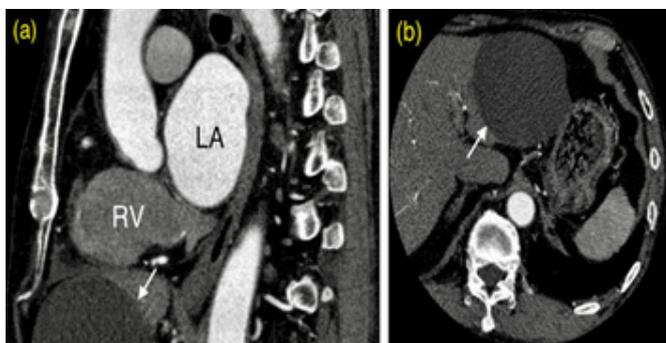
Computed tomography revealed a hepatic cyst (7 cm in diameter) in the lateral segment of the liver (arrow) 1a: Sagittal plane; 1b: Axial plane. (LA: Left Atrium, RV: Right Ventricle).
